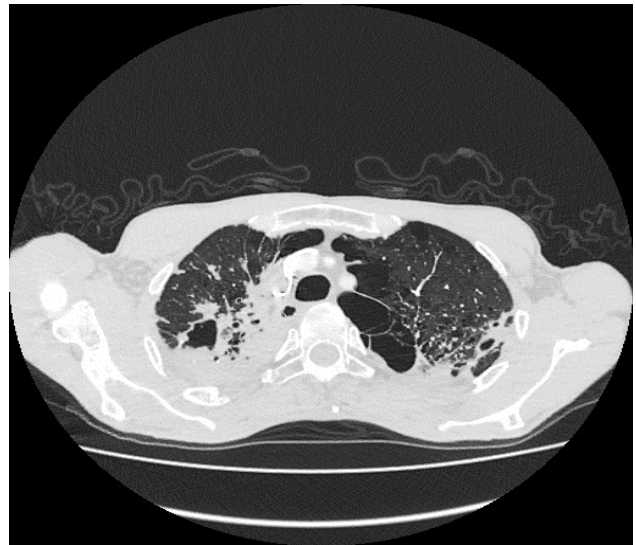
Patient 2 (chest CT scan).
